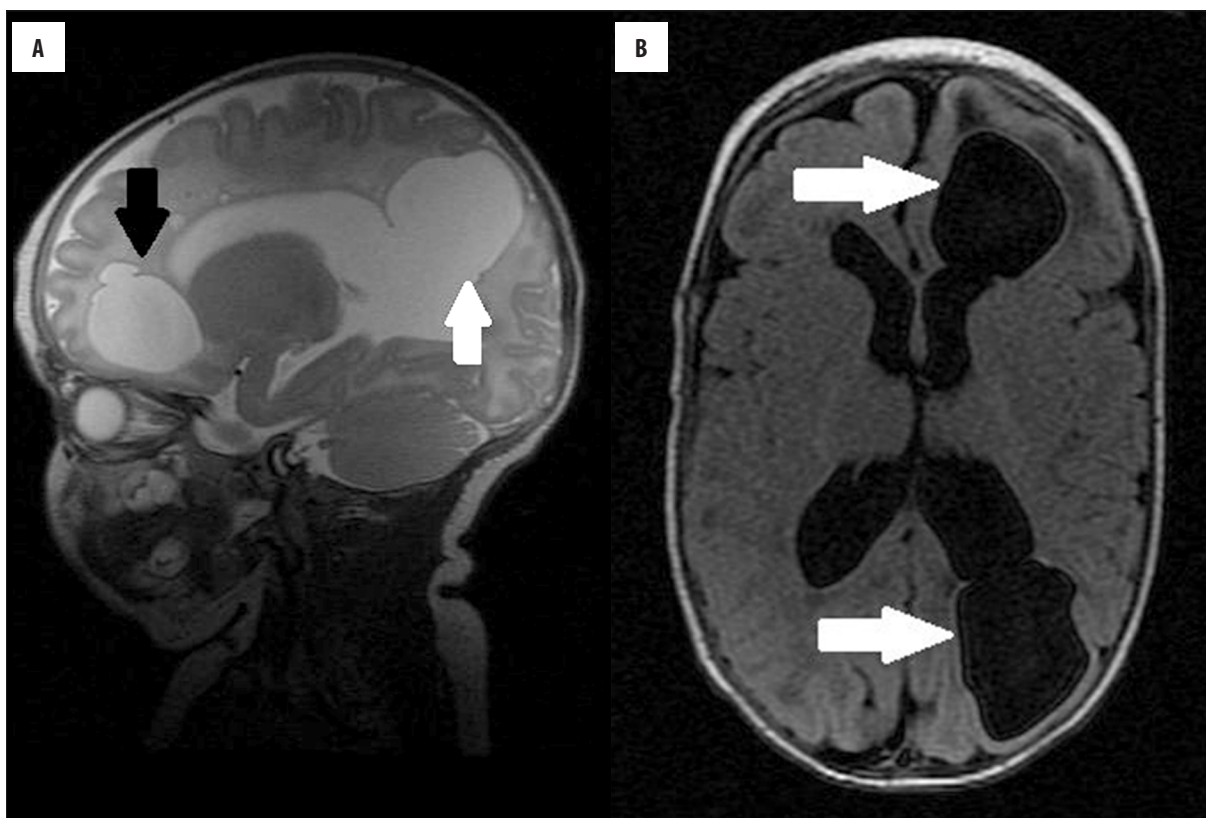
Brain MRI of the patient on the 88th day of life. (A) T2-weighted image in the sagittal plane showing cavities in the left frontal lobe (black arrow) and in the left occipital lobe (white arrow), bordering the left lateral ventricle. (B) FLAIR image in the coronal plane.
